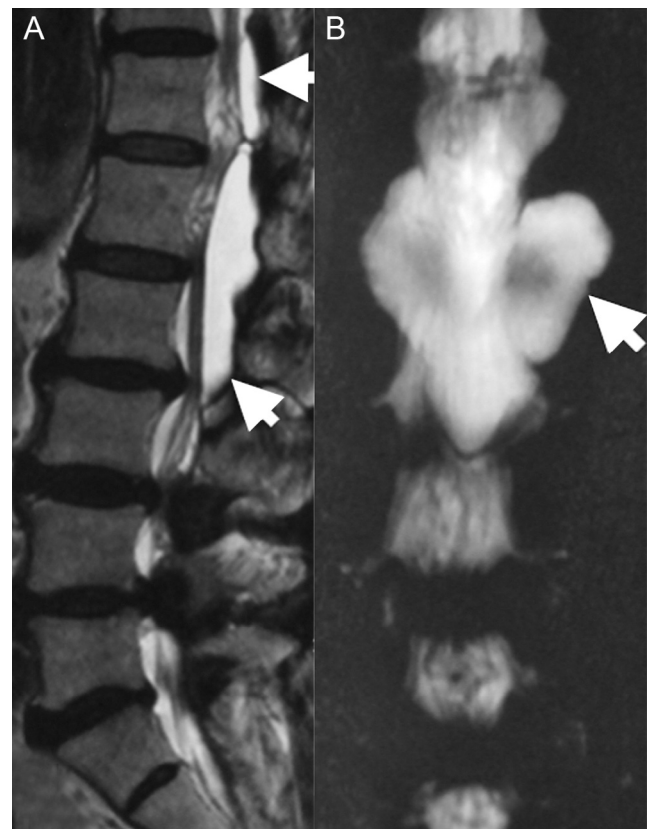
(A) T2-weighted magnetic resonance image showing an isointense cystic lesion with cerebrospinal fluid (arrows) of T12 to L2. (B) Myelographic effect on magnetic resonance image; the communication (arrow) between the arachnoid space and the cystic lesion is apparent.
